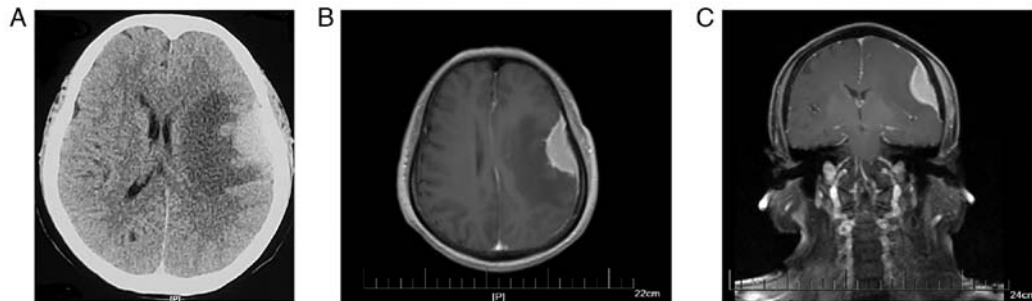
MRI and CT scans of subdural mass before craniotomy. (A) Cranial CT showing a mass lesion in the left temporal lobe with an edema lesion surrounded. (B) Axial and (C) coronal MRI showing a relatively homogeneous enhancing 18x43 mm-sized mass exhibiting dural tail sign under the left frontal parietal medial plate and thickening of the adjacent cranial plate.
